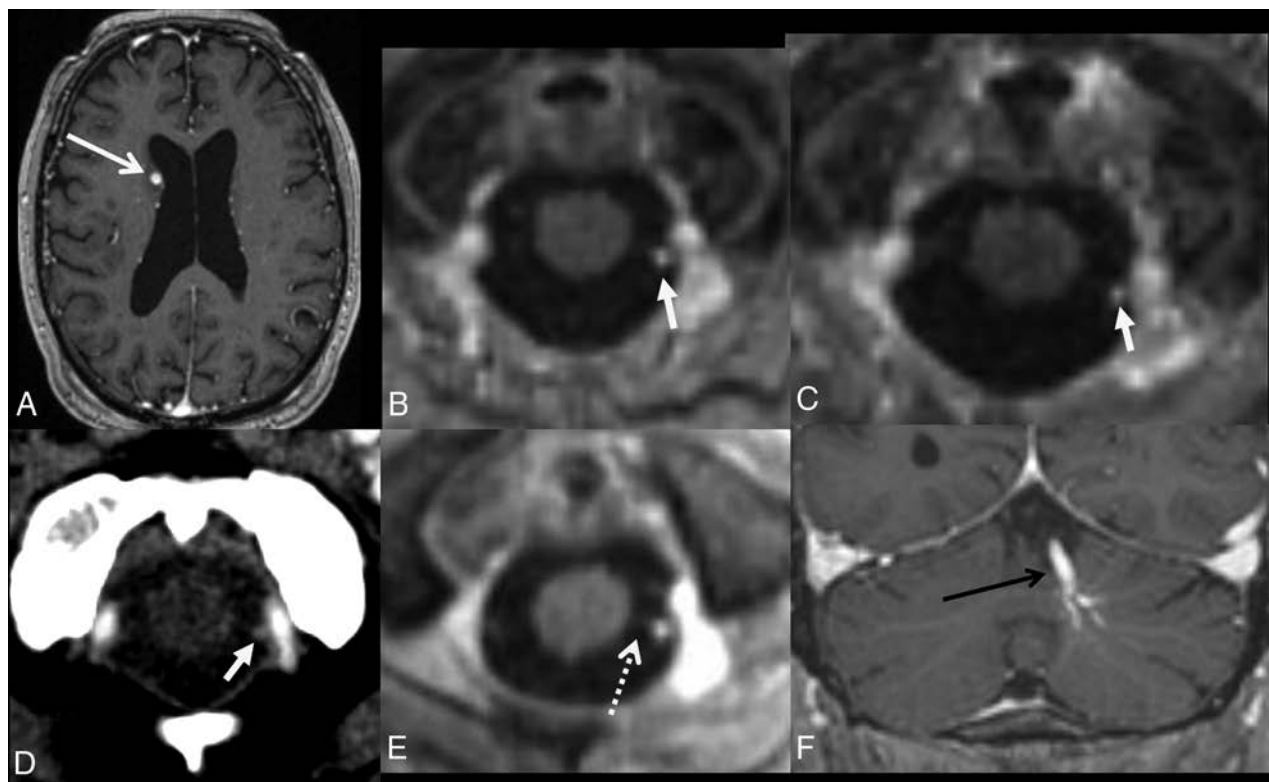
Axial T1 postcontrast volumetric imaging from a radiation-planning MR imaging for a metastatic melanoma lesion (A, *arrow*) demonstrates a 2-mm enhancing focus posterior to the left vertebral artery in the foramen magnum (B, *arrow*). This was unchanged from a study 18 months earlier (C, *arrow*) and was seen on a venous phase soft-tissue neck CT (D, *arrow*). Thin-section postcontrast imaging reveals its close proximity to a barely perceptible upper cervical nerve root (E, *dashed arrow*). A presumably coincidental developmental venous anomaly is seen in the left cerebellar hemisphere (F, *black arrow*).
